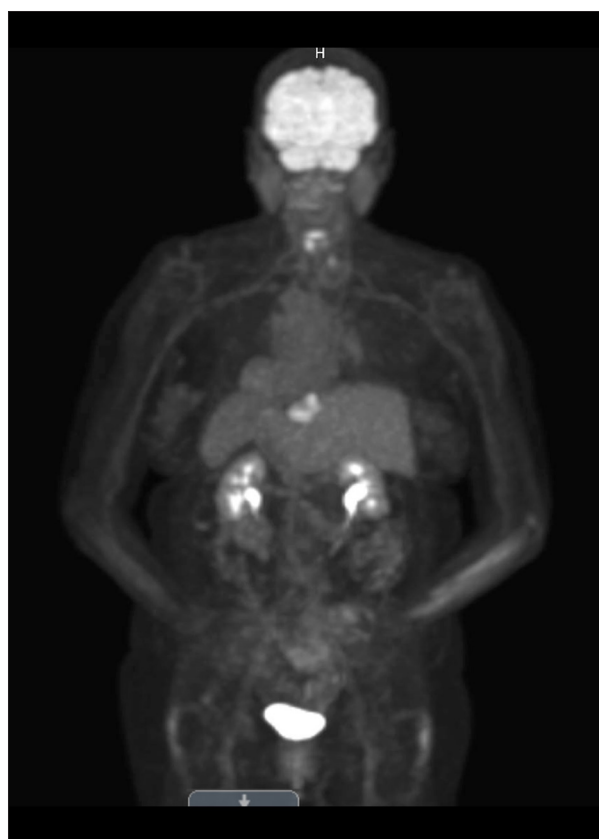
Maximum intensity projection PET-CT image showing hypermetabolic activity in the midline presternal soft tissue.
